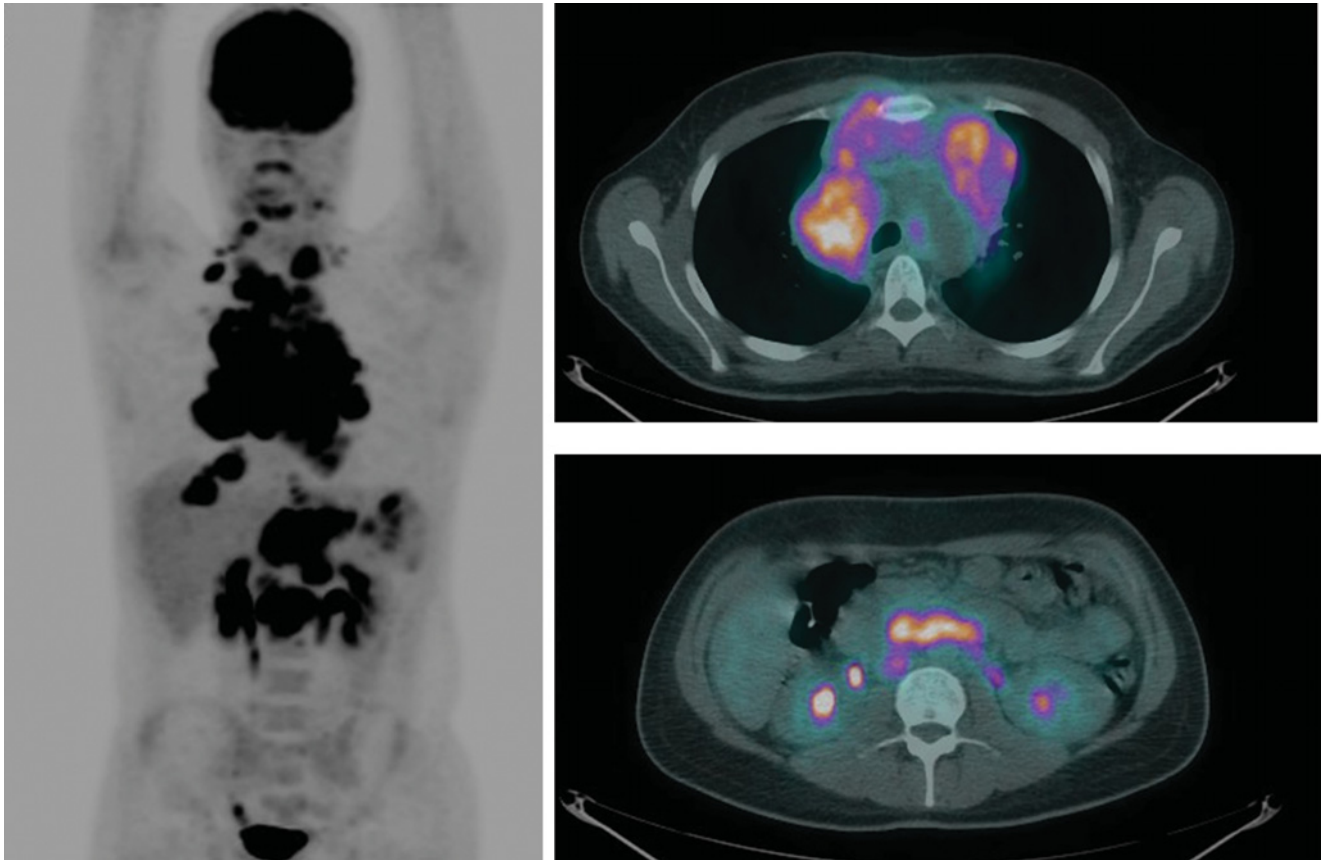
PET scan images of patient with stage III Hodgkin lymphoma showing FDG-avid cervical, mediastinal, mesenteric and retroperitoneal lymphadenopathy.
